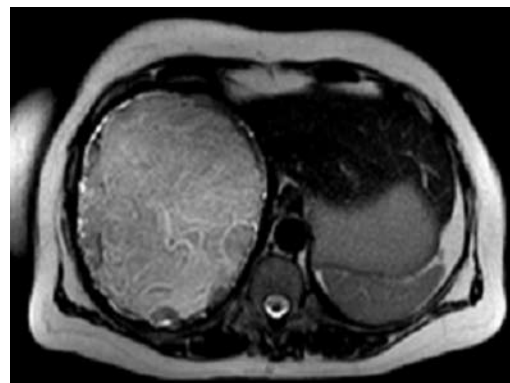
35-year-old woman living in an endemic region. Axial T2-weighted magnetic resonance image show the hydatid cyst that occupies almost the entire right lobe of the liver with thickened pericyst and multiple floating membranes inside the lesion (type II).
